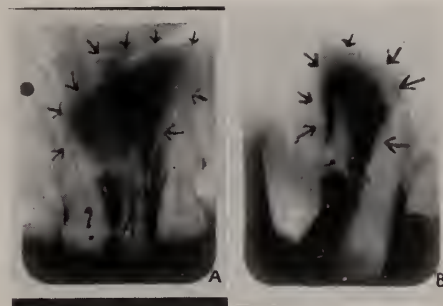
Roentgenograms showing infected radicular cysts which developed from pulpless teeth.
